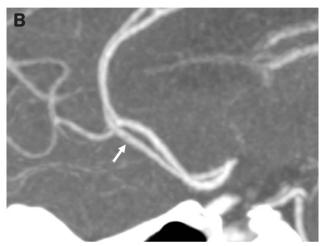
(A) The CT angiography revealed a fusiform aneurysmal dilatation (arrow) in the right A2 segment of the anterior cerebral artery. (B) The follow-up CT angiography 1 year later showed resolution of the dissecting aneurysm.
